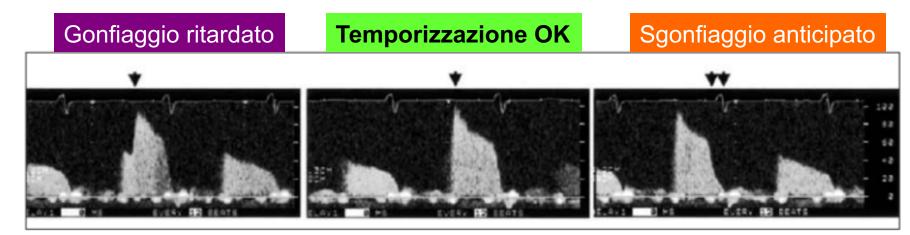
Aggiustamento della temporizzazione durante registrazione del flusso coronarico (tratto da M. Takeuchi, Y. Nohtomi, H. Yoshitani et al. "Enhanced Coronary Flow Velocity During Intra-Aortic Balloon Pumping Assessed by Transthoracic Doppler Echocardiography" J Am Coll Cardiol 2004; 43: pp. 368 –76): A) Gonfiaggio ritardato: è possibile identificare un'incisura tra il flusso di decelerazione diastolica e il flusso corrispondente al picco diastolico generato dal contropulsatore (indicato dalla freccia)
